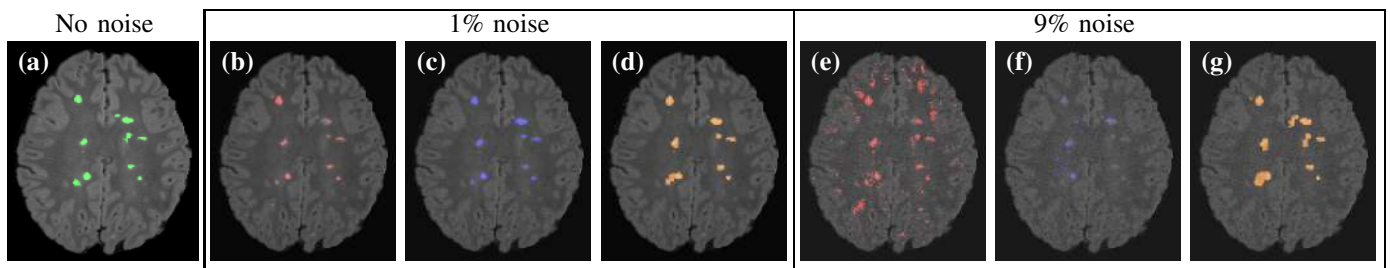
Segmentation with noise. In (a) the original FLAIR image with GT. We show results with 1% of additive Rician noise (b)–(d), and with 9% (e)–(g). We compared with respect to Lesion-Toads (red, (b), (e)), LST (blue, (c), (f)), and the proposed method (orange, (d), (g)).
